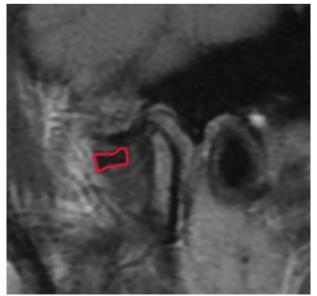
Sagittal section of MRI revealing anterior disc displacement without reduction in the open mouth position
